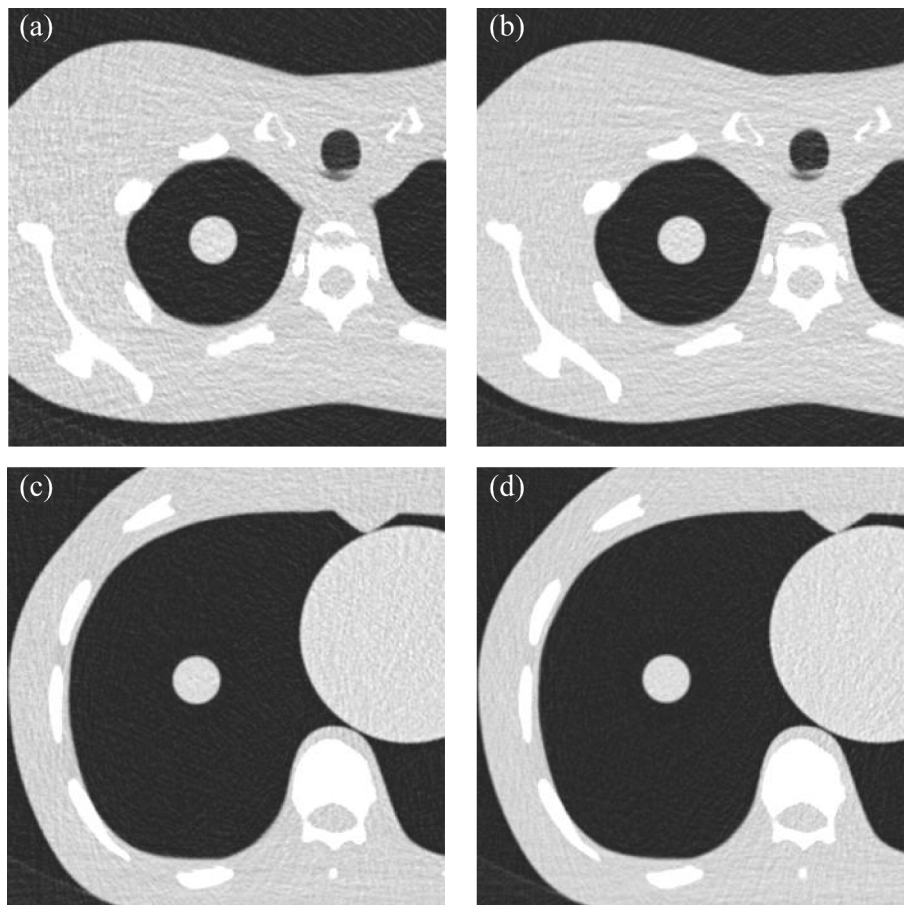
Typical CT images obtained at 0.4 mGy with a window condition for the mediastinum (window width = 500 HU, window center = 30 HU) for (a) NF120kV and (b) TF100kV at the AS; (c) NF120kV and (d) TF100kV at the BS.
